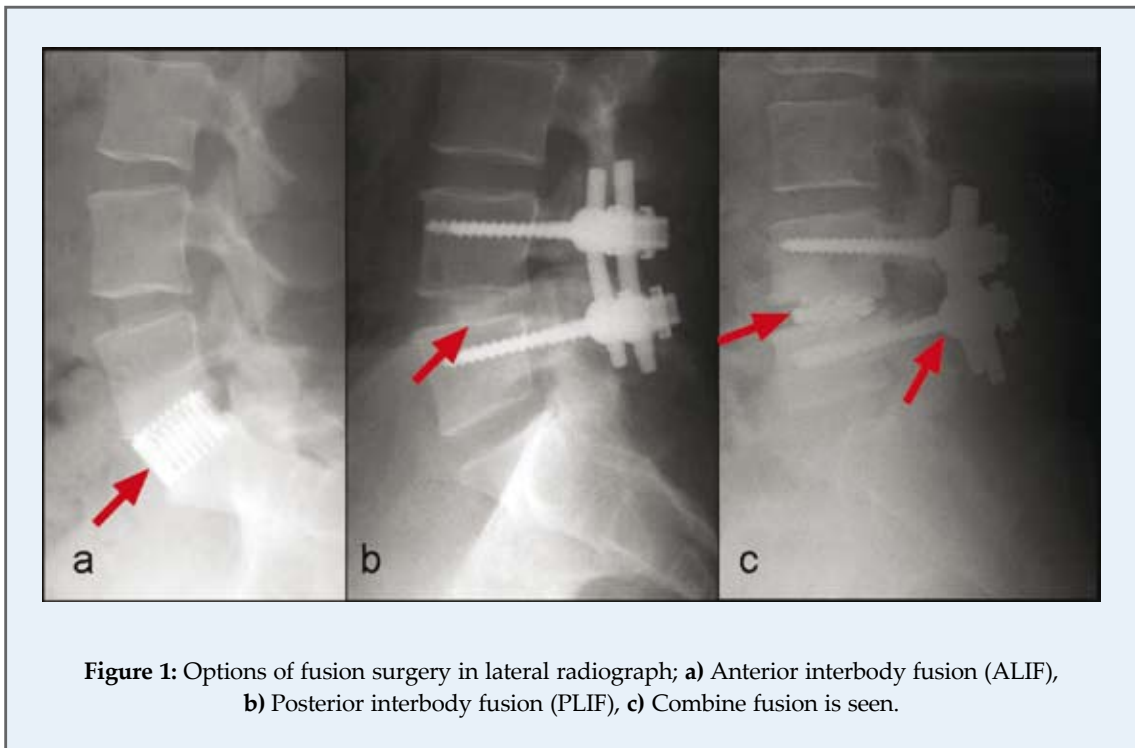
Options of fusion surgery in lateral radiograph; a) Anterior interbody fusion (ALIF), b) Posterior interbody fusion (PLIF), c) Combine fusion is seen.
